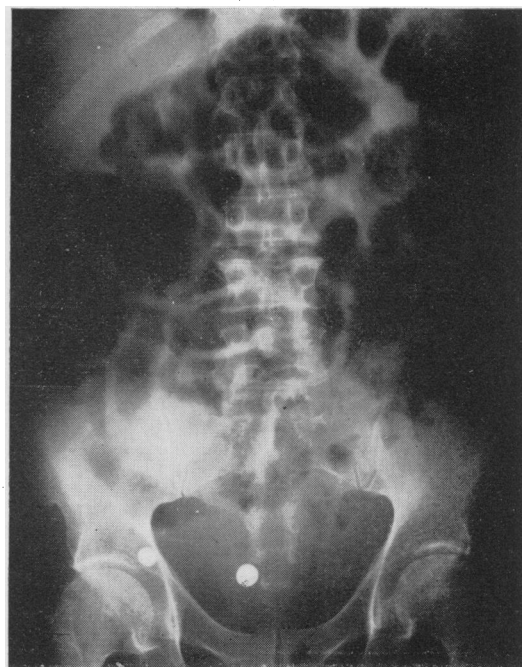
Plain radiograph of the abdomen (case 3) shows gaseous distension of both the small and large intestine, suggesting paralytic ileus.
